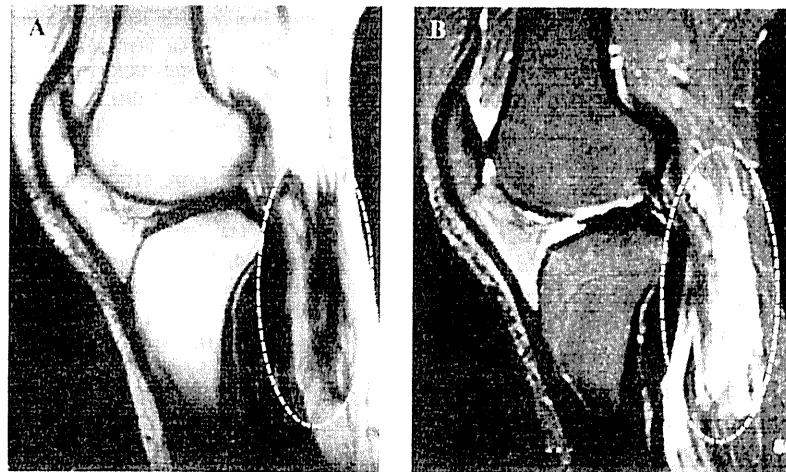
MRI showed an intramuscular tumor within the lateral gastrocnemius muscle with intermediate signal-intensity on T1-weighted images (A) and heterogeneous high signal-intensity on T2-weighted images (B).
